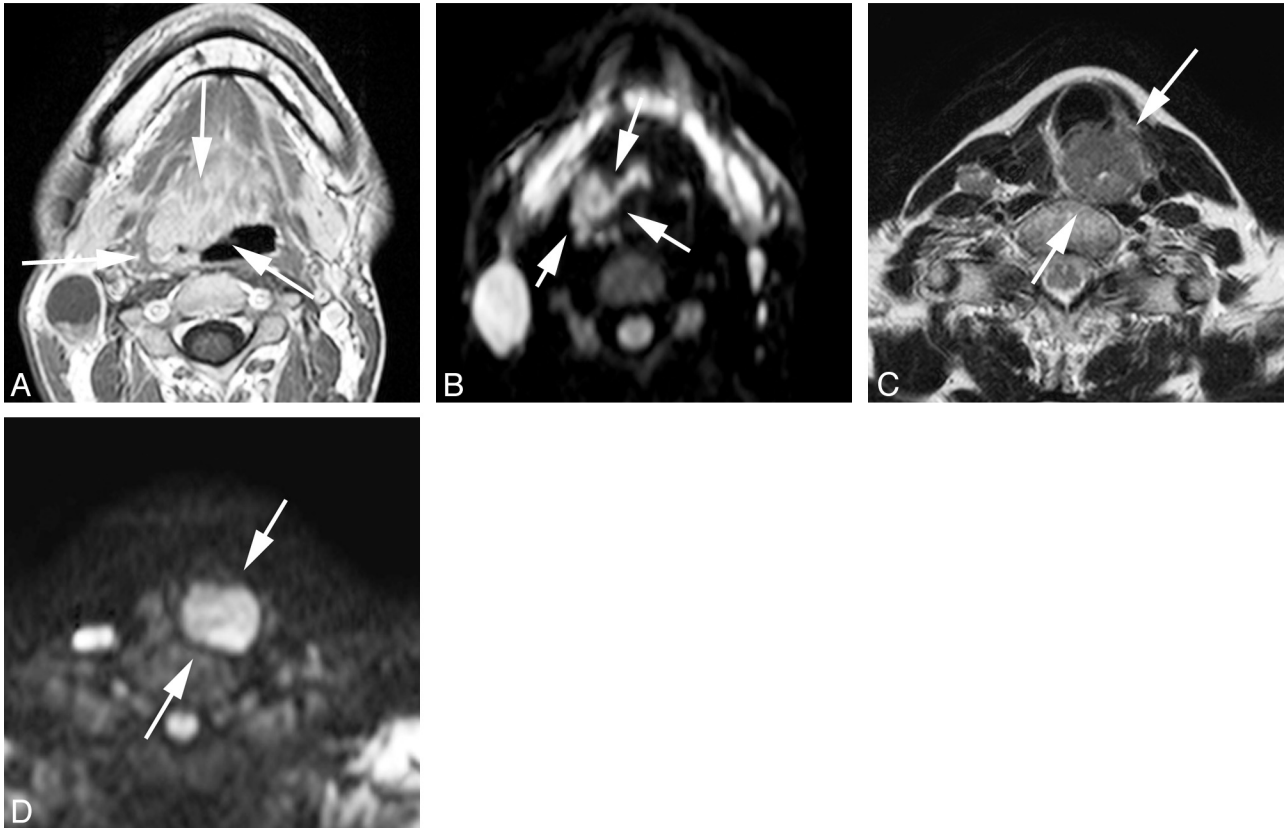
Representative images of local control and failure cases obtained before treatment. *A* and *B*, Transverse gadolinium-enhanced T1-weighted and DWI ($b = 1000 \text{ s/mm}^2$) of a local-control case (oropharyngeal cancer, 30s, male, T4N2M0, high ADC before treatment = $0.63 \times 10^{-3} \text{ mm}^2/\text{s}$). *C* and *D*, T2-weighted and DWI ($b = 1000 \text{ s/mm}^2$) of a local-failure case (hypopharyngeal cancer, 60s, female, T4N2M0, high ADC before treatment = $0.99 \times 10^{-3} \text{ mm}^2/\text{s}$). The arrows indicate primary lesions.
